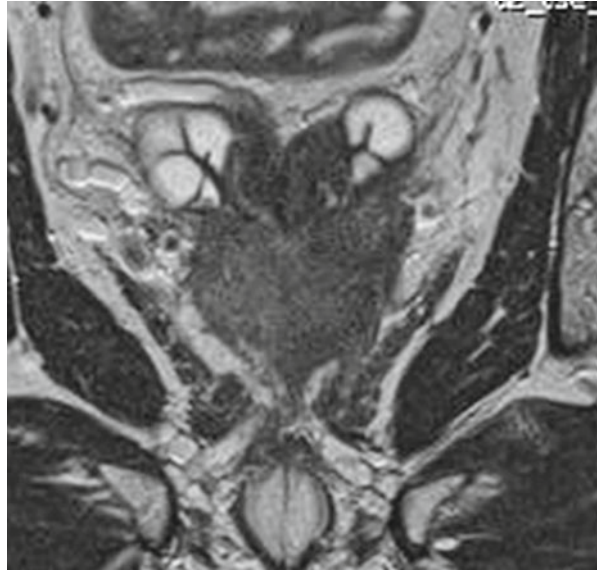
Left Transition Zone tumour on (a) T2-MRI and (b) DWI-MRI
